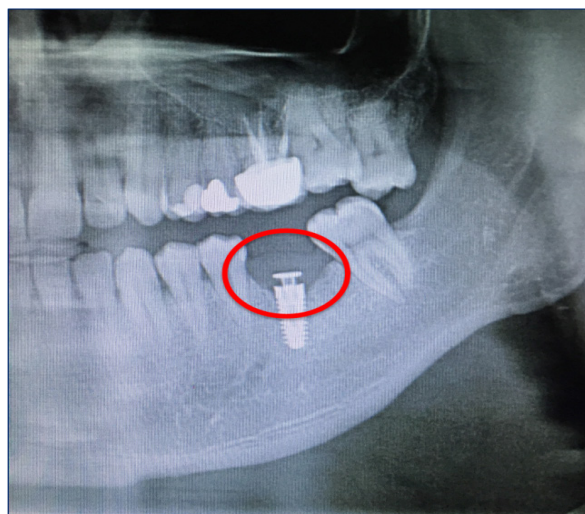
Pre-operative view of the radiograph
